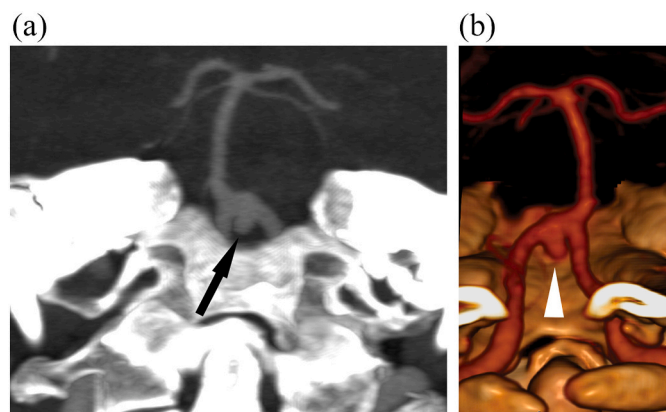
a) Coronal maximum intensity projection of 7 mm of CT angiography exam, arrow points to the VBJ aneurysm, b) volume rendering of CT angiography exam, dorsal view, arrowhead points to the wide necked VBJ aneurysm.
